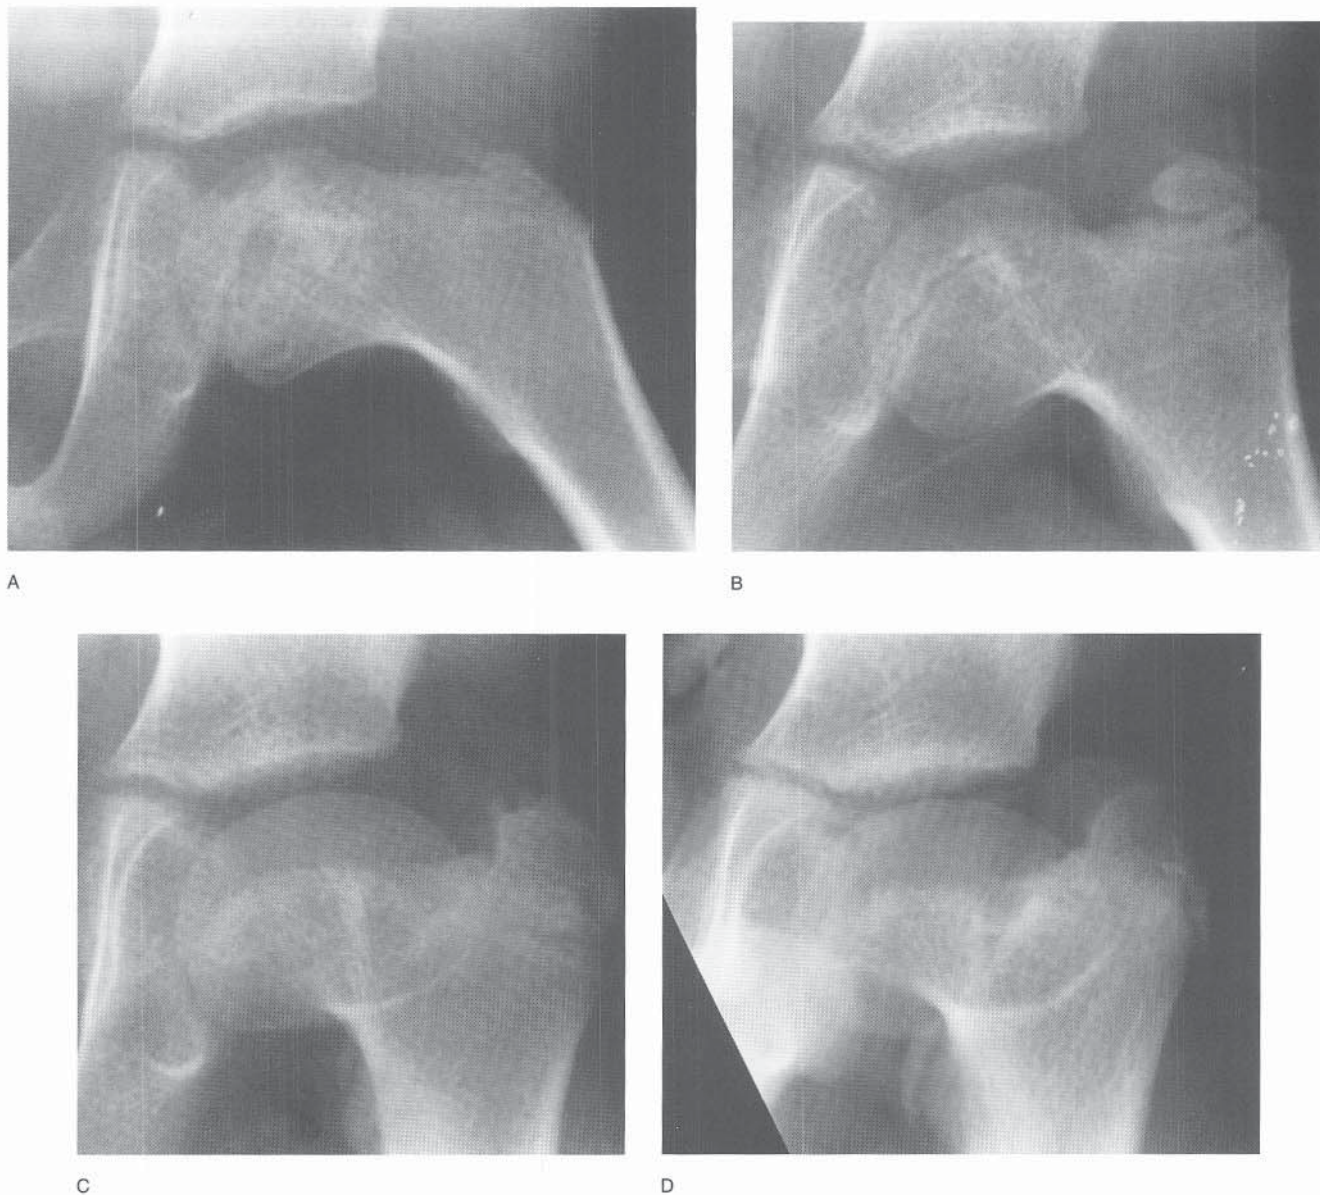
Growth arrest in patient with Legg-Calvé-Perthes disease. A, AP radiograph of a 6-year-old boy with mild involvement of the left hip. There is a dense area laterally in the metaphysis and epiphysis. B, AP radiograph of the boy at age 8 years shows an apparent bridge across the physis and growth disturbance of the femoral neck. C, AP radiograph at 10 years of age shows further loss of growth of the upper femoral neck, with a valgus tilt of the femoral head. D, AP radiograph at 13 years of age shows trochanteric overgrowth and a short femoral neck, with a valgus tilt to the femoral head.
